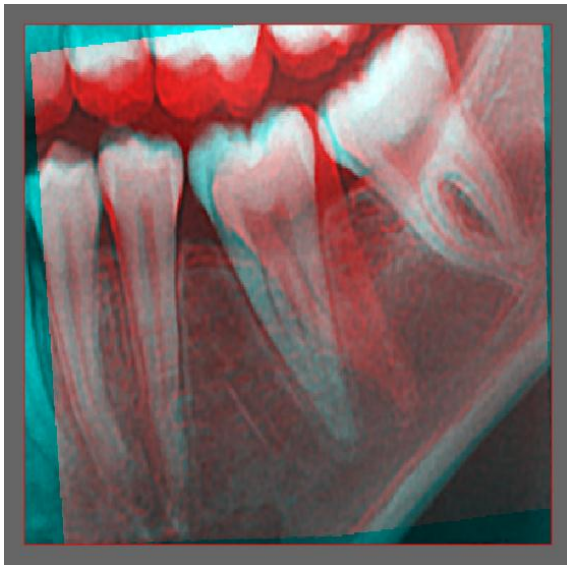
"Registration" (Geometric matching) of pre & post treatment radiographs
